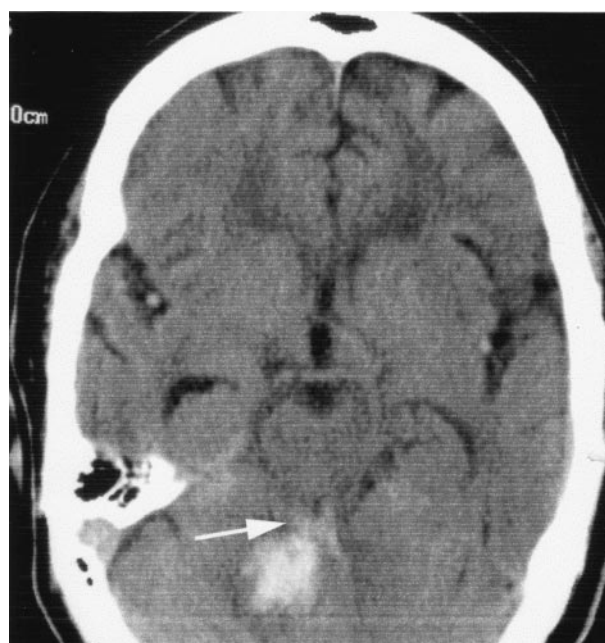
Images obtained in a 75-year-old woman who fell at home and presented with nausea, vomiting, and lethargy. On neurologic examination, she was lethargic but arousable, opening her eyes, responding to voice, and following simple commands. She had a right-sided Babinski sign and a GCS score of 14. Her medical history was significant for atrial fibrillation, for which she was receiving coumadin. Nonenhanced CT scan shows a right cerebellar hemorrhage that extends into the fourth ventricle (arrow). The patient's coagulation status was reversed with vitamin K and fresh frozen plasma. A few days later, she developed hydrocephalus, which responded to treatment with a ventriculostomy tube. Her condition improved, and she was discharged to a skilled nursing facility.
